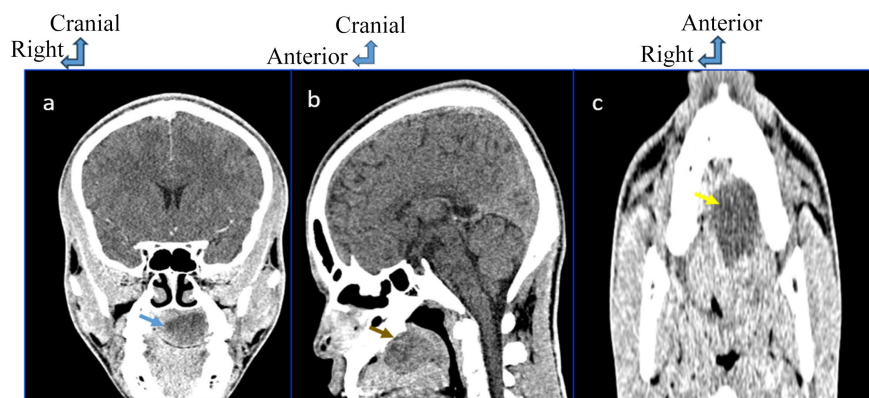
CT scan of the facial skeleton; (a) coronal section: blue arrow indicating a palatal tumor; (b) sagittal section: brown arrow indicating a palatal tumor; (c) axial section: yellow arrow indicating a palatal tumor.
